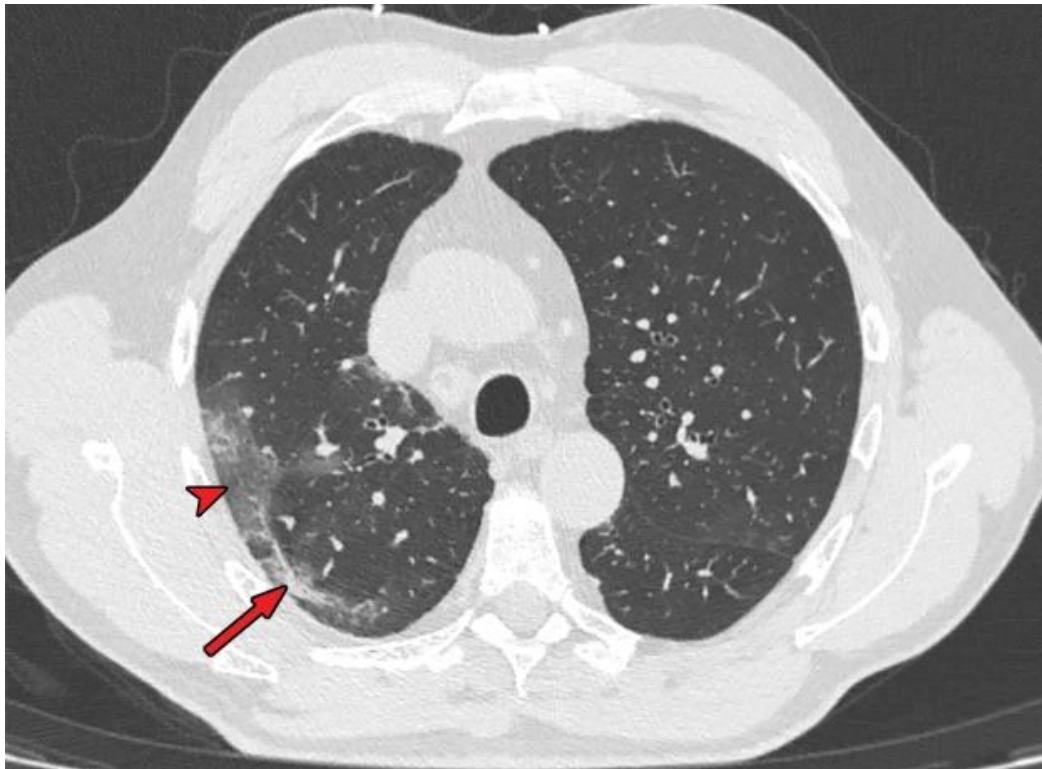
HRCT chest for male 47 years old show the first case recover from COVID-19
